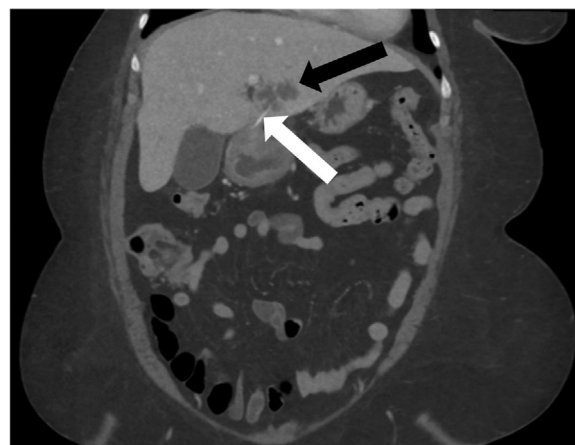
Computed tomography (coronal view) demonstrating a linear hyperdense object (white arrow) extending from the gastric pylorus into a heterogeneous left hepatic lobe lesion (black arrow)
